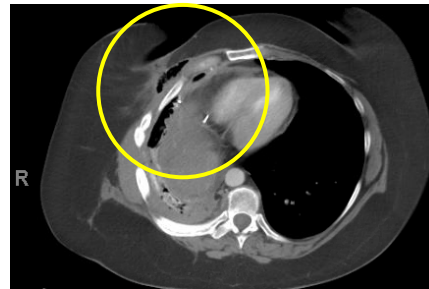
CT prior to the first surgery showed air from right breast wound to chest wall
